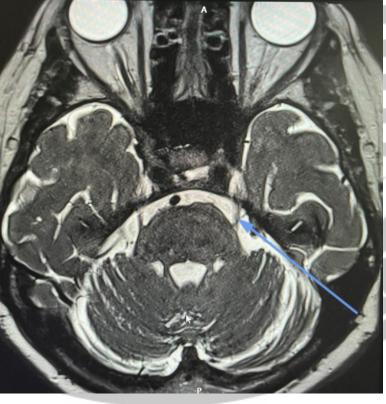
MRI brain T2 image in axial view Blue arrow shows the suspected lesion in MRI
